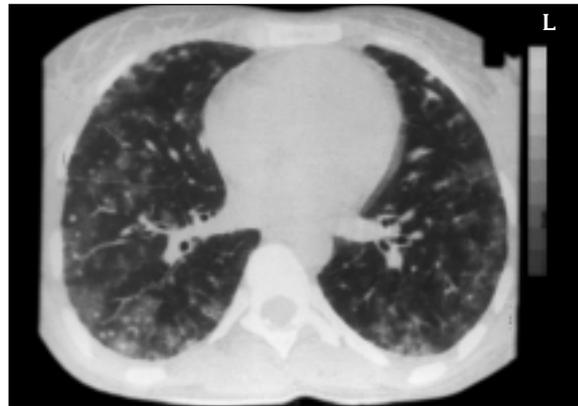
The high resolution computed tomography (HRCT) on admission.
